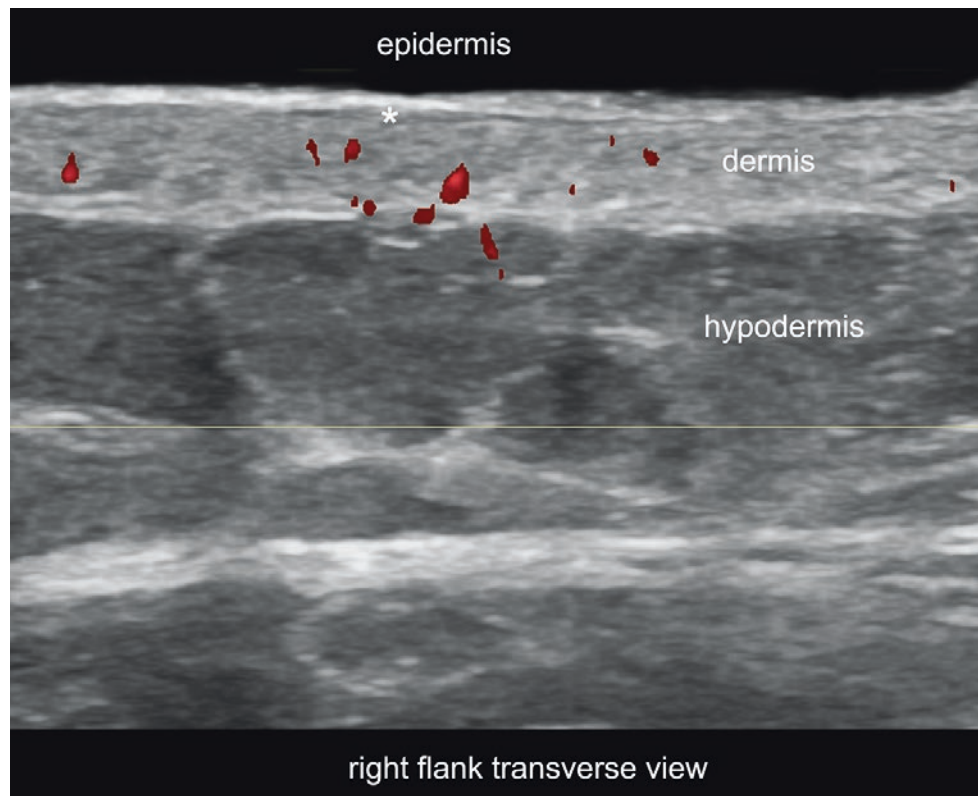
Active psoriatic plaque. Color Doppler ultrasound (right flank; transverse view) demonstrates epidermal and dermal thickening with dermal hypoechoogenicity (*asterisks*) and hypervascularity at the plaque.
